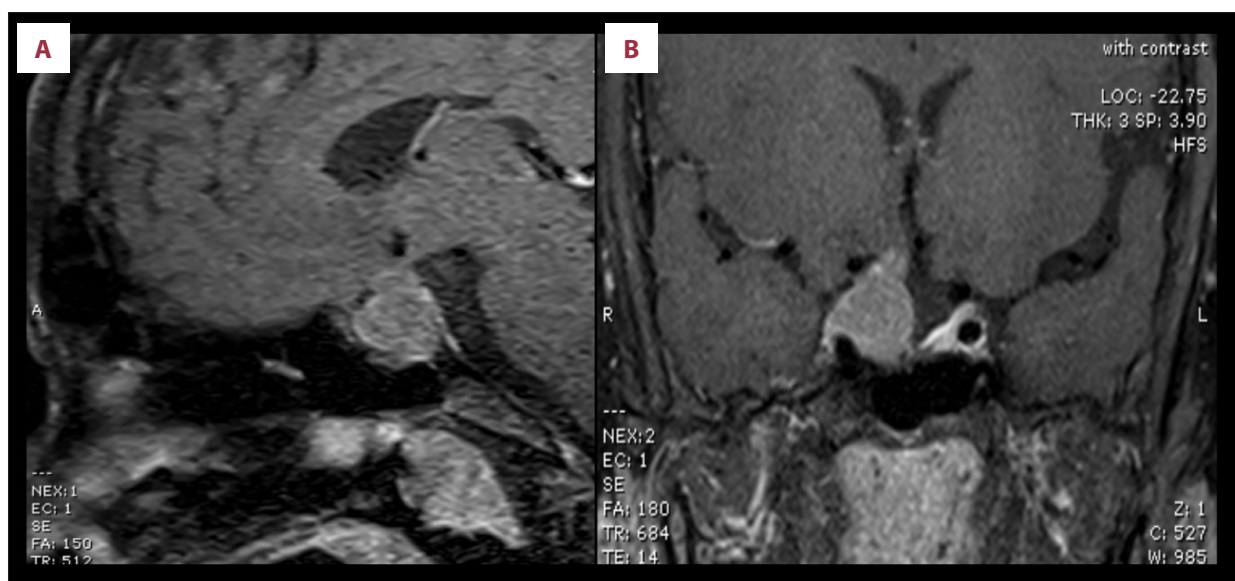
(A) Pre-operative contrast-enhanced sagittal T1-weighted magnetic resonance imaging (MRI) of the sellar region demonstrating a pituitary macroadenoma arising from the pituitary gland with suprasellar extension, consistent with recurrent growth hormone-secreting adenoma. (B) Pre-operative contrast-enhanced coronal T1-weighted MRI of the sellar region showing a recurrent pituitary macroadenoma measuring approximately 15 × 10 mm in the right pituitary hemisphere, with lateral extension and encasement of the right internal carotid artery.
